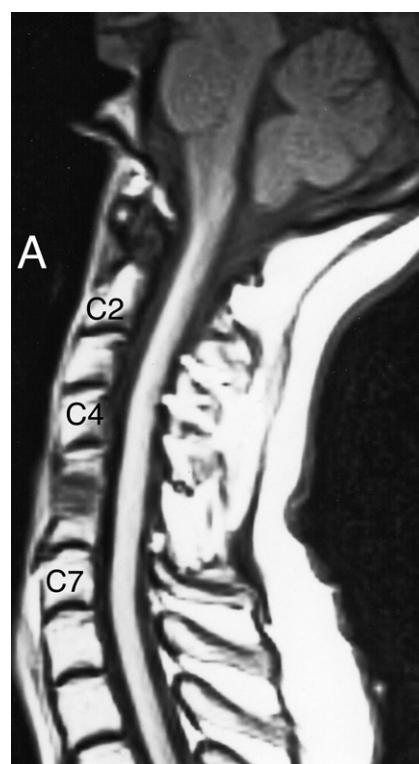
Cervical spine MRI sagittal image following the Cloward revision. Note the mild reversal of the curvature of the mid-cervical region.
